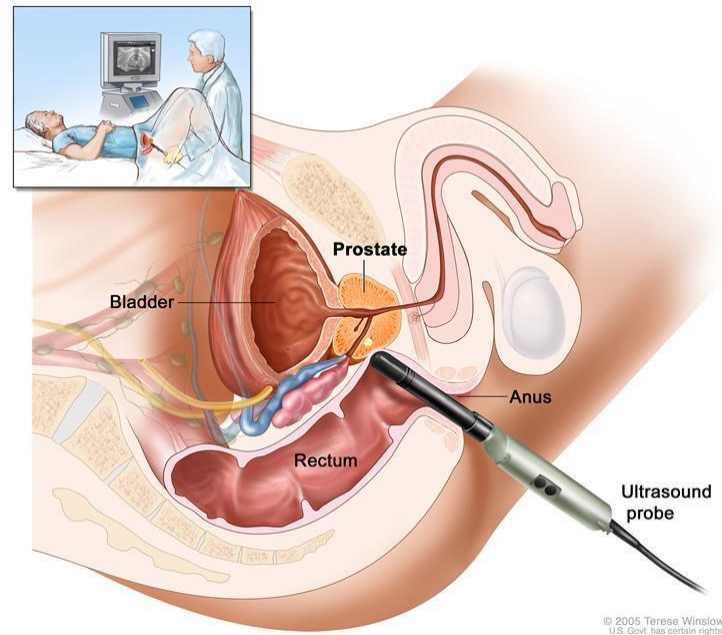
Trans-rectal ultrasound (TRUS) (NCI, 2005).
